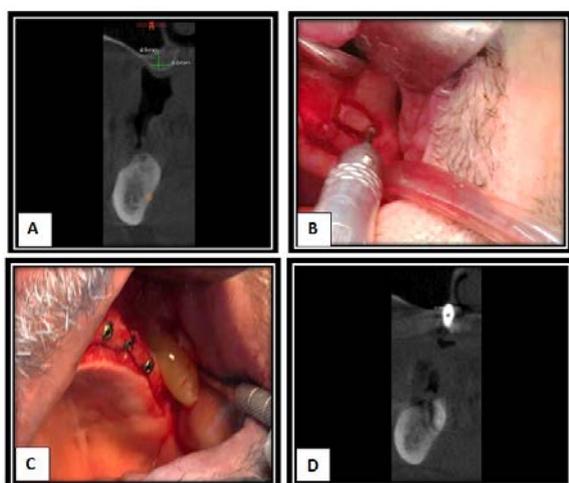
(A) Coronal view of CBCT revealed preoperative height and width of residual alveolar bone. (B) Lateral osteotomy window preparation. (C) Insertion of PRF clot after implant placement. (D) Coronal view of CBCT 24 weeks after sinus augmentation reveals the dental implant is completely surrounded by bone.
